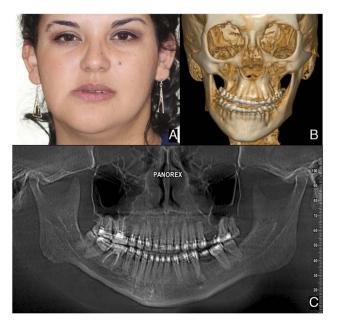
(A) Facial asymmetry related to uniliteral osteochondromas. (B) Computed tomography showing the class III trend and the facial asymmetry. (C) Orthopantomography showing differences in the condylar size and mandibular ramus morphology.
